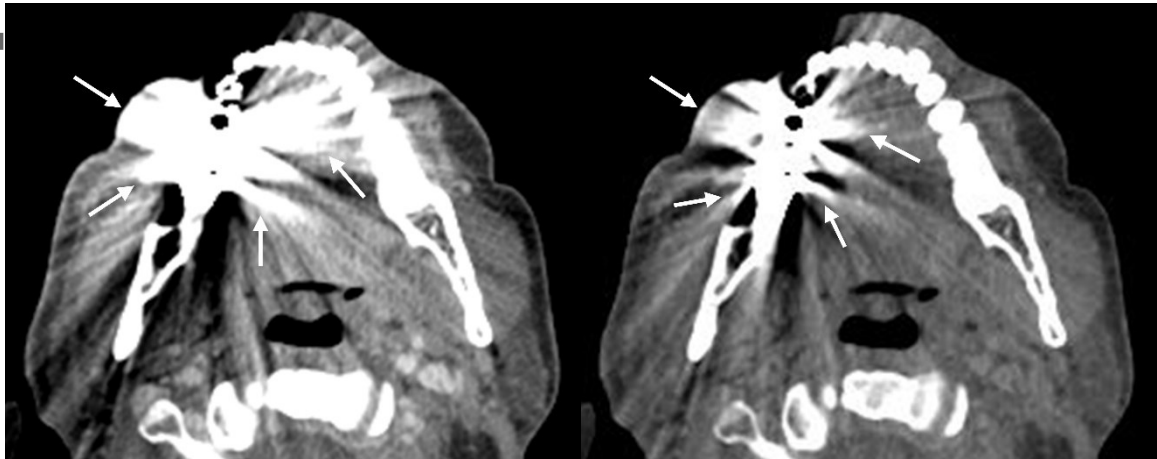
52-year-old male. Compared to 70-keV virtual monochromatic imaging, which approximates conventional CT (A), 140-keV virtual monochromatic imaging (B) shows reduced dental metal artifacts (arrows).
